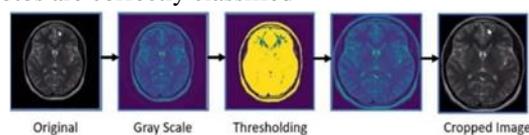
Pre-processing stages of MRI images
